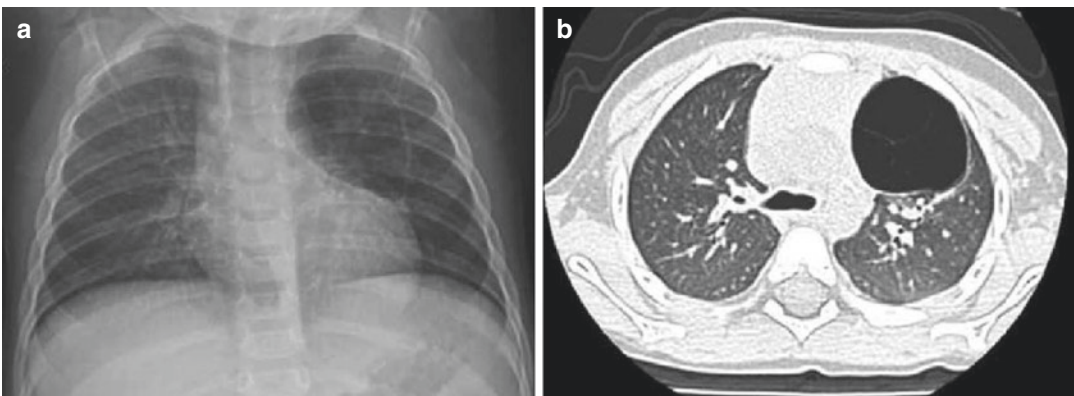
Cystic adenomatoid malformation. (a) Chest X-ray of 1-year-old infant with persistent cough shows a radiolucent region in the superior left lobe. (b)
